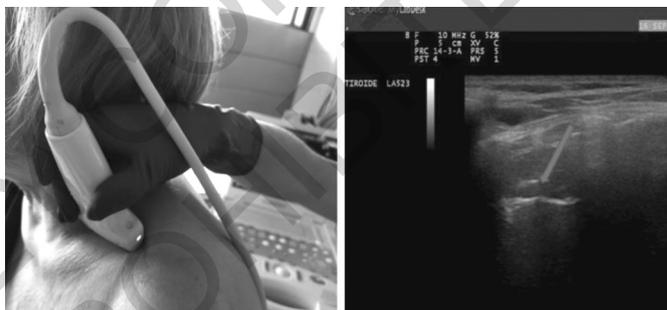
CUS exploration of the re-expansion of lung apex through supraclavicular approach. CUS: chest ultrasound.
